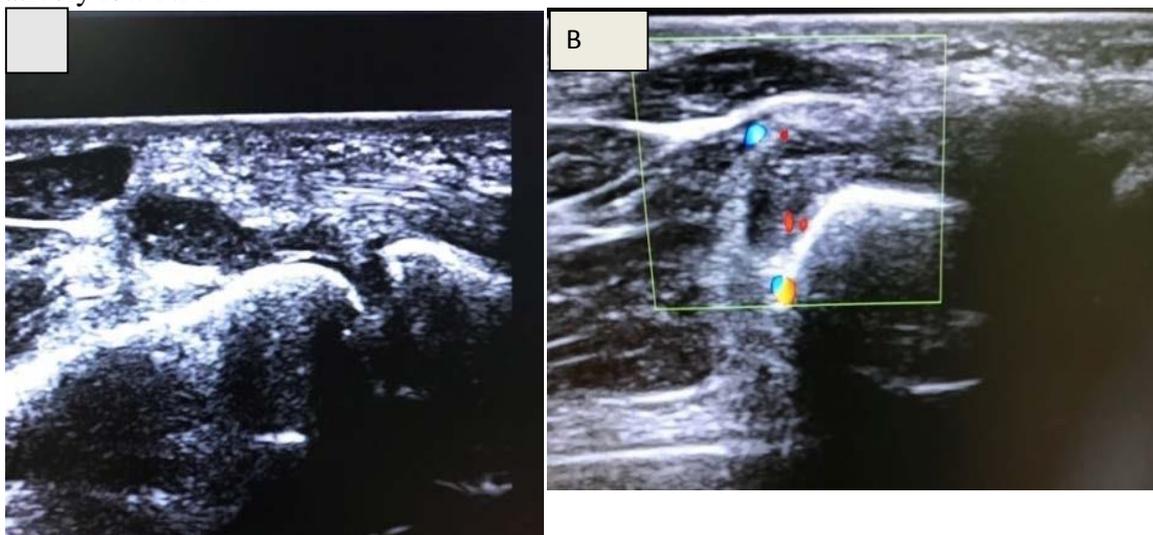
US of the 2nd MCPJ shows, a) nodular synovial thickening, b) Color Doppler shows hyperemia (synovitis).
